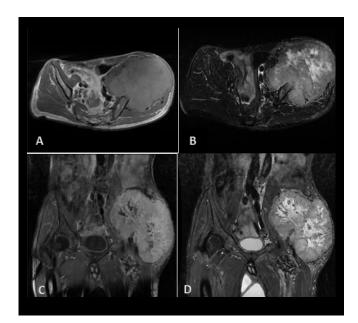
Pelvic MRI in axial T1 (A), axial T2 (B), coronal T1 FS (C), axial T2 (D) slices showing a left sacroiliac mass affecting the small and medium gluteal muscles, approximately oval in shape, well-defined, heterogeneous with intermediate T1 signal and T2 hypersignal. It extends to the iliac wing and contacts the femoral head without signs of invasion.
